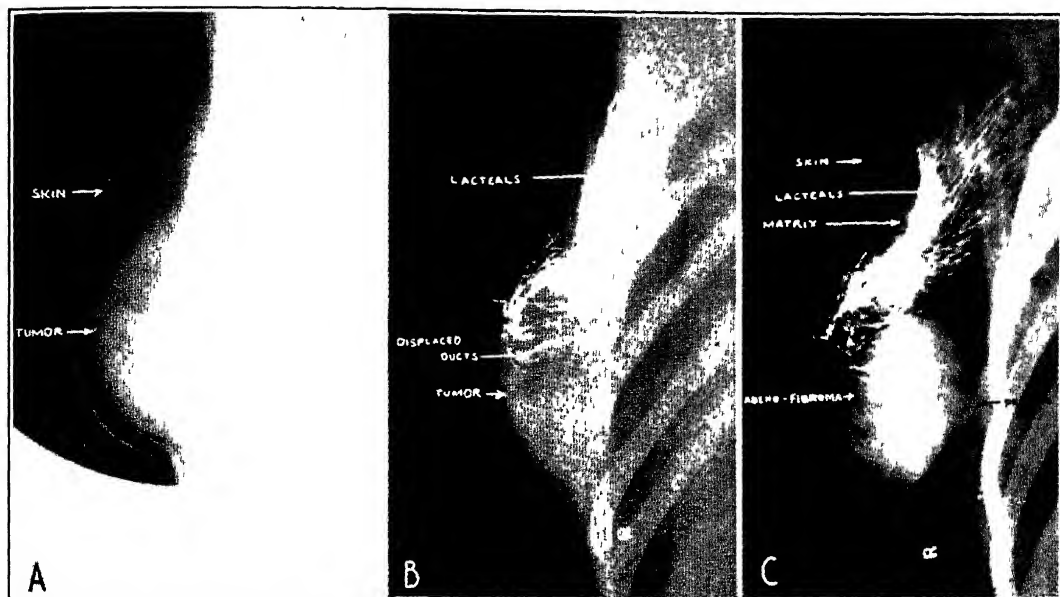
A*, Roentgenogram shows a dense well-encapsulated tumor without denoting its origin *B*, The ducts do not communicate with the tumor but spread over its surface and then ascend into the axilla Displacement of the ducts indicates benignancy *C*, Combined thorotrast and CO₂ visualizations reveal the duct-bearing part of the gland to be normal, while a dense encapsulated tumor can be seen arising from the lower matrix Observe the accessory vascular pedicle attaching the neoplasm to the chest wall (Am J Roentgenol, March, 1938.)
